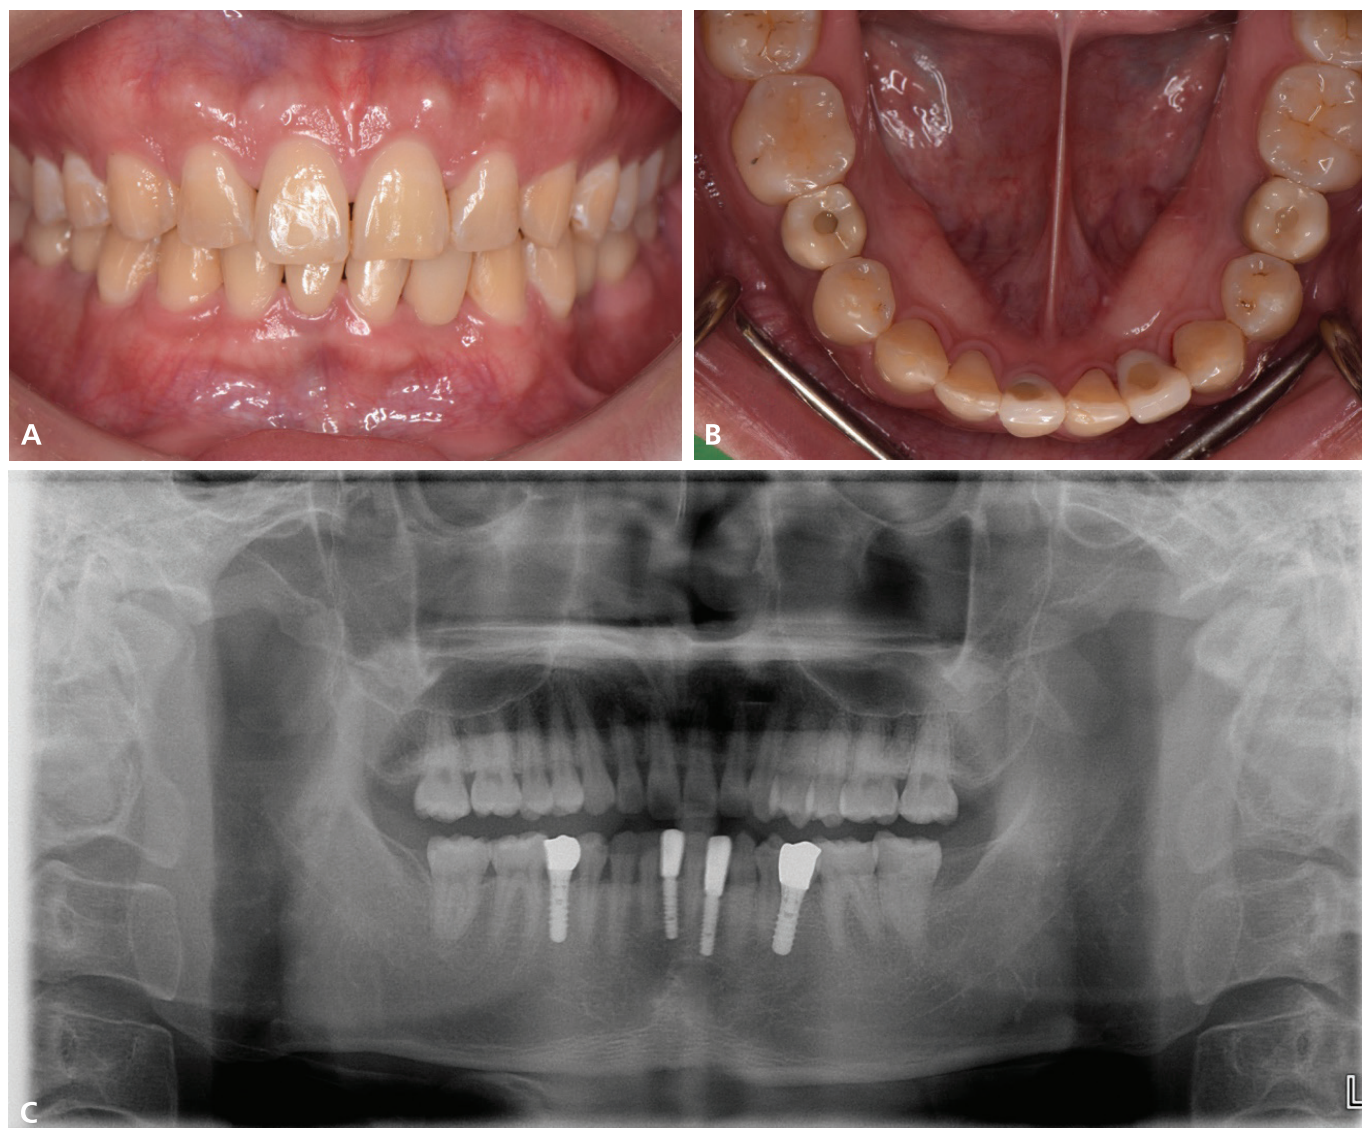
Three years after crown delivery. (A) Frontal view. (B) Mandibular occlusal view. (C) panoramic radiograph.
